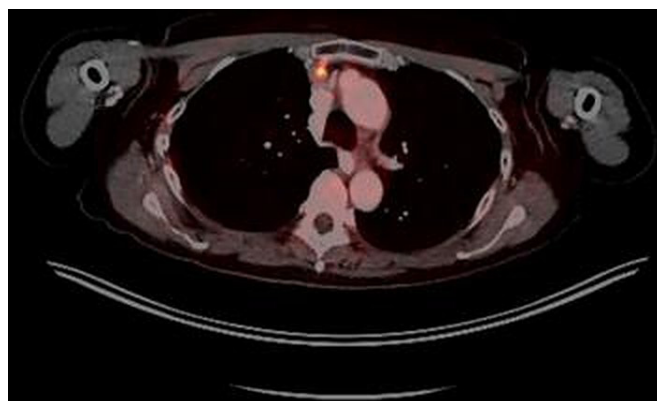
Interval PET/CT scan exhibiting stable size of lymph nodes. PET/CT, positron emission tomography/CT.
